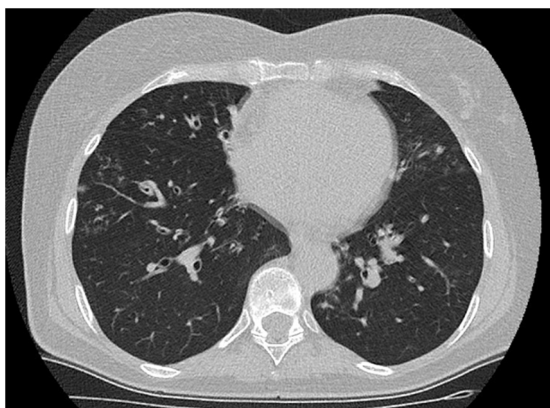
CT section showing bronchiectasis and predominantly peripheral nodular images in the right lower lobe.
